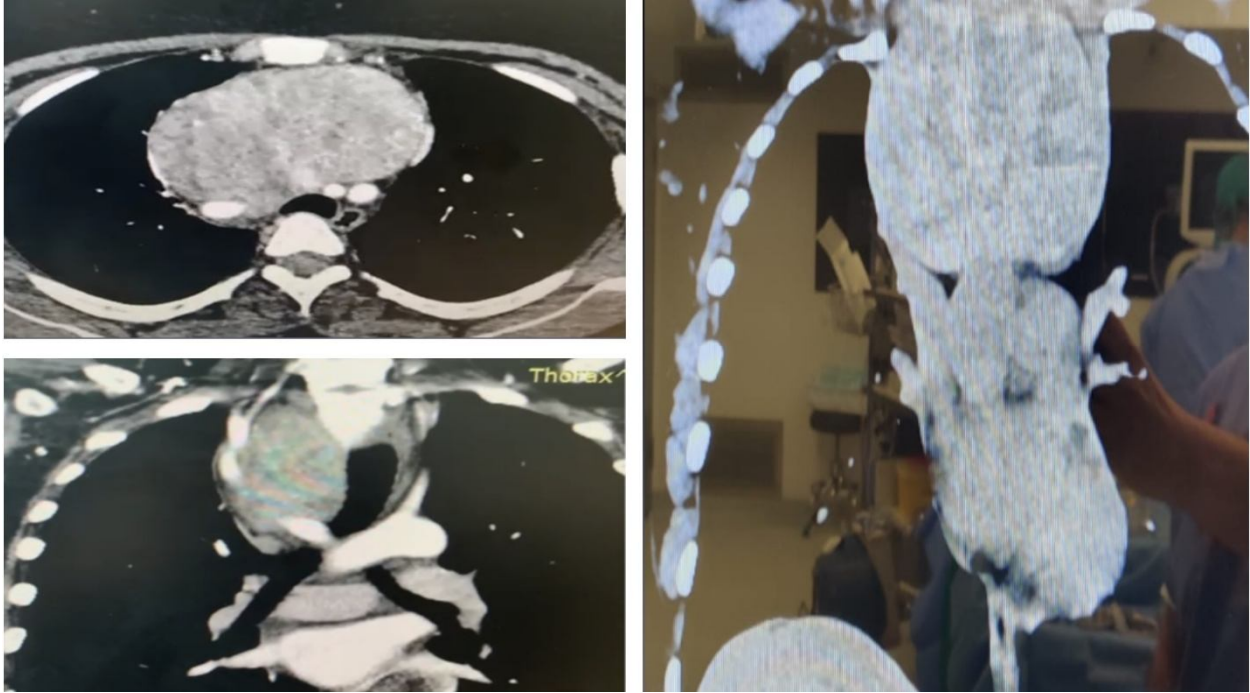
CT scan showing large multinodular goiter with mass effect in a form of left tracheal shift and SVC compression
